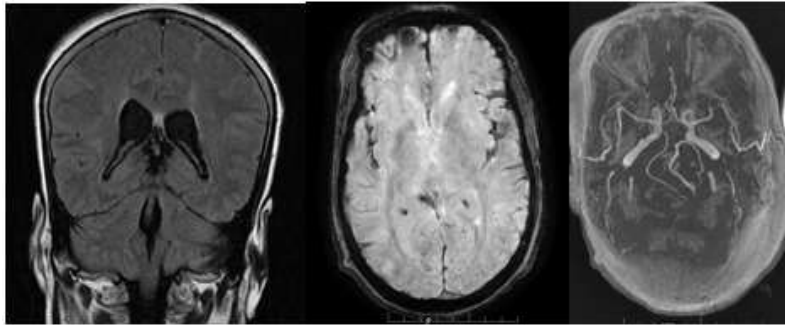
20 year old female postpartum c/o severe headache Coronal FLAIR hyperintensities along cortical sulci, blooming along bilateral sylvian fissure and cortical sulci. MRA did not reveal any aneurysm.
